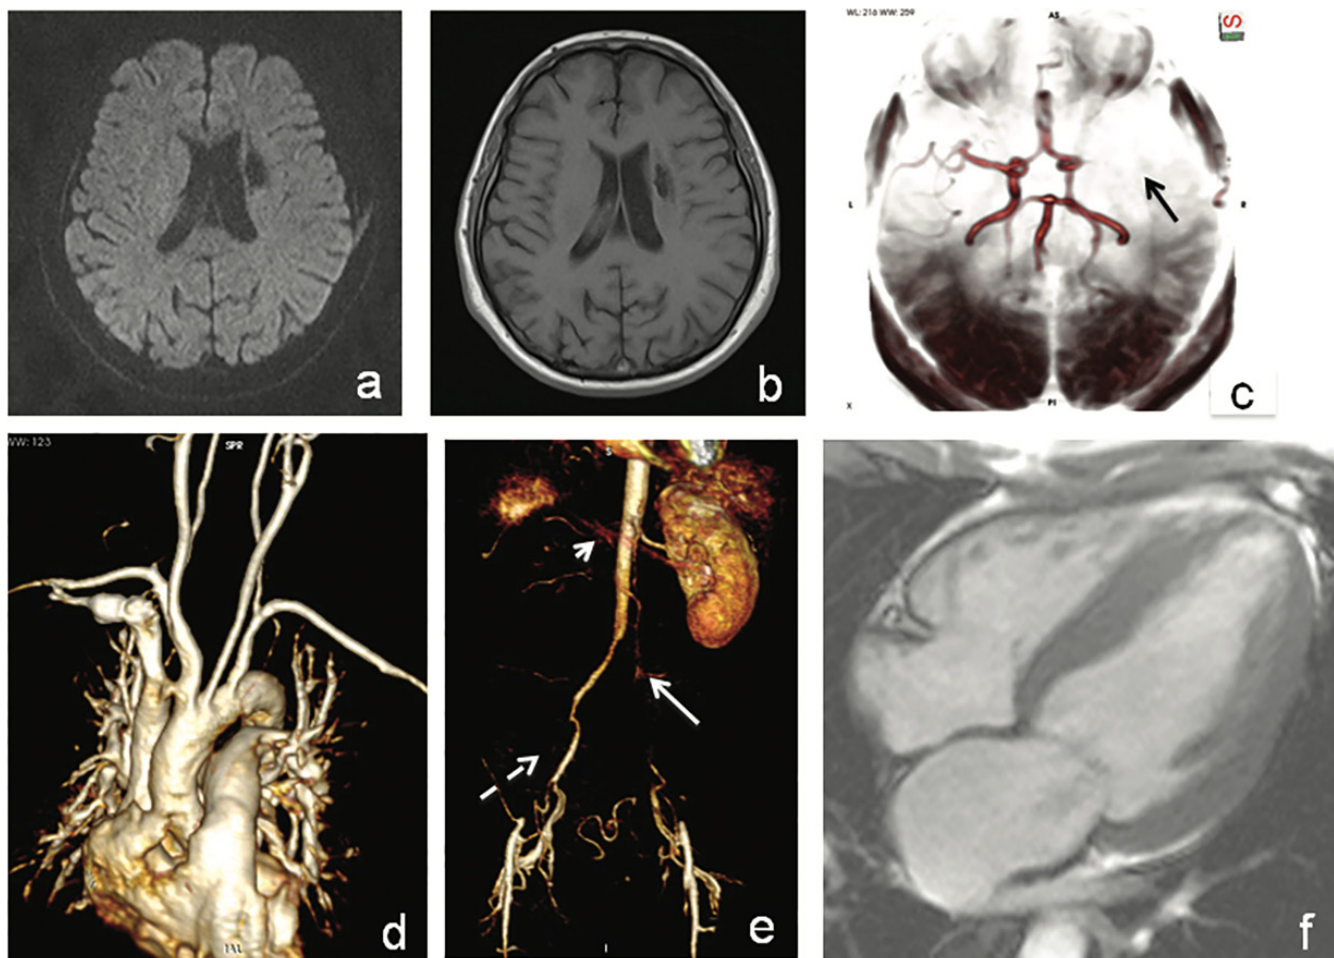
29-year-old male with type IV TAK of the angiographic classification. DWI sequence (a) and T1 (b), show an area of encephalomalacia adjacent to the left lateral ventricle corresponding to a chronic ischaemic vascular event. The cerebral MRA(c) shows lack of signal from the left middle cerebral artery (black arrow). Angiographic reconstructions (d, e) show normal diameter and morphology of the thoracic-abdominal aorta and supra-aortic vessels. The right renal artery (arrowhead) is not observed with corresponding renal atrophy. Occlusion of the left common iliac artery and right external iliac artery (white dashed arrow and arrow). True FISP sequence in 4 chambers in systole (f) showing concentric hypertrophy and systolic dysfunction of the left ventricle. LVEF 36% and mitral regurgitation.
